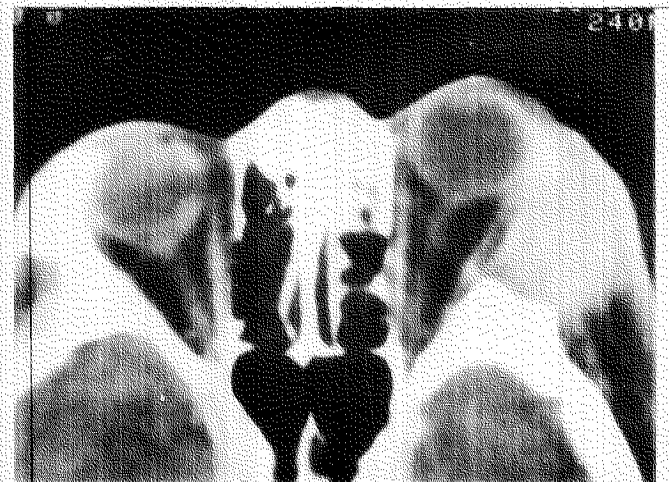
ORBIT CT (9 MONTHS POSTTREATMENT)
